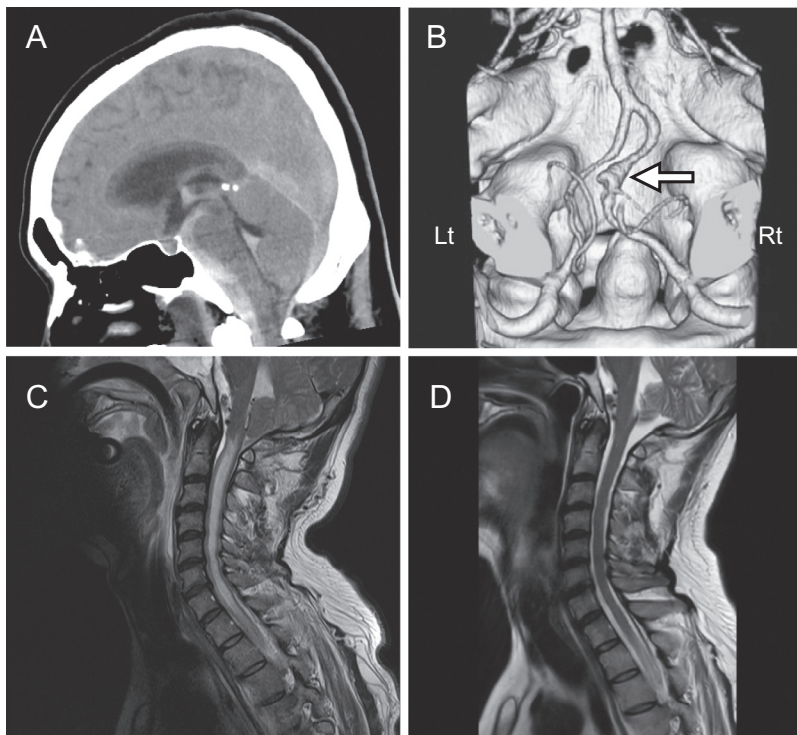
(A) Sagittal view of head computed tomography (CT) showing subarachnoid hemorrhage (SAH) with hematoma in the third and fourth ventricles and prepontine cistern. In the cerebellum, dorsal SAH seems to push the cerebellum anterior-caudally and reduce the posterior cranial fossa volume. (B) CT angiography showing a dissected aneurysm of the right vertebral artery involving the origin of the right posterior inferior cerebellar artery. (C) Sagittal T2-weighted magnetic resonance imaging (MRI) of the cervical and upper thoracic cord taken at 14 days after the onset of SAH shows syringomyelia from C1 to T4 levels, with tonsillar herniation. (D) Sagittal T2-weighted MRI of the cervical and upper thoracic cord taken at 11 days after the removal of the lumbar drain shows the complete disappearance of the herniation of the cerebellar tonsil and spinal syringomyelia.
